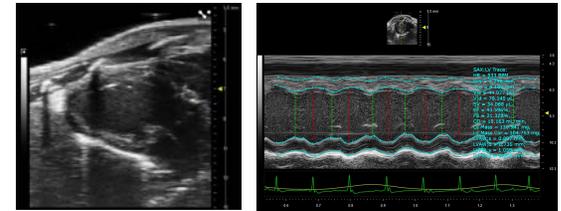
Echocardiography. Representative B mode image of cardiac long axis (left). Representative M mode image of cardiac short axis with tracing of wall movement and measured cardiac parameters (right).
